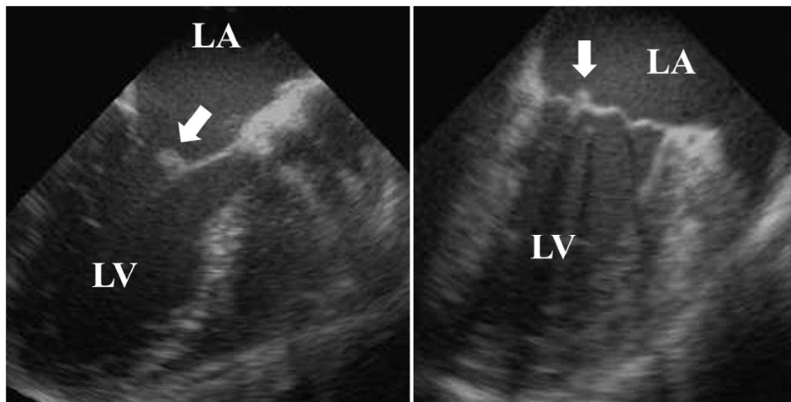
TEE (day 1): A high echo structure (↗) with a size of about 4 mm movable is attached to the anterior cusp of the mitral valve. Abbreviations; LA, left atrium; LV, left ventricle; TEE, transesophageal echocardiography.
